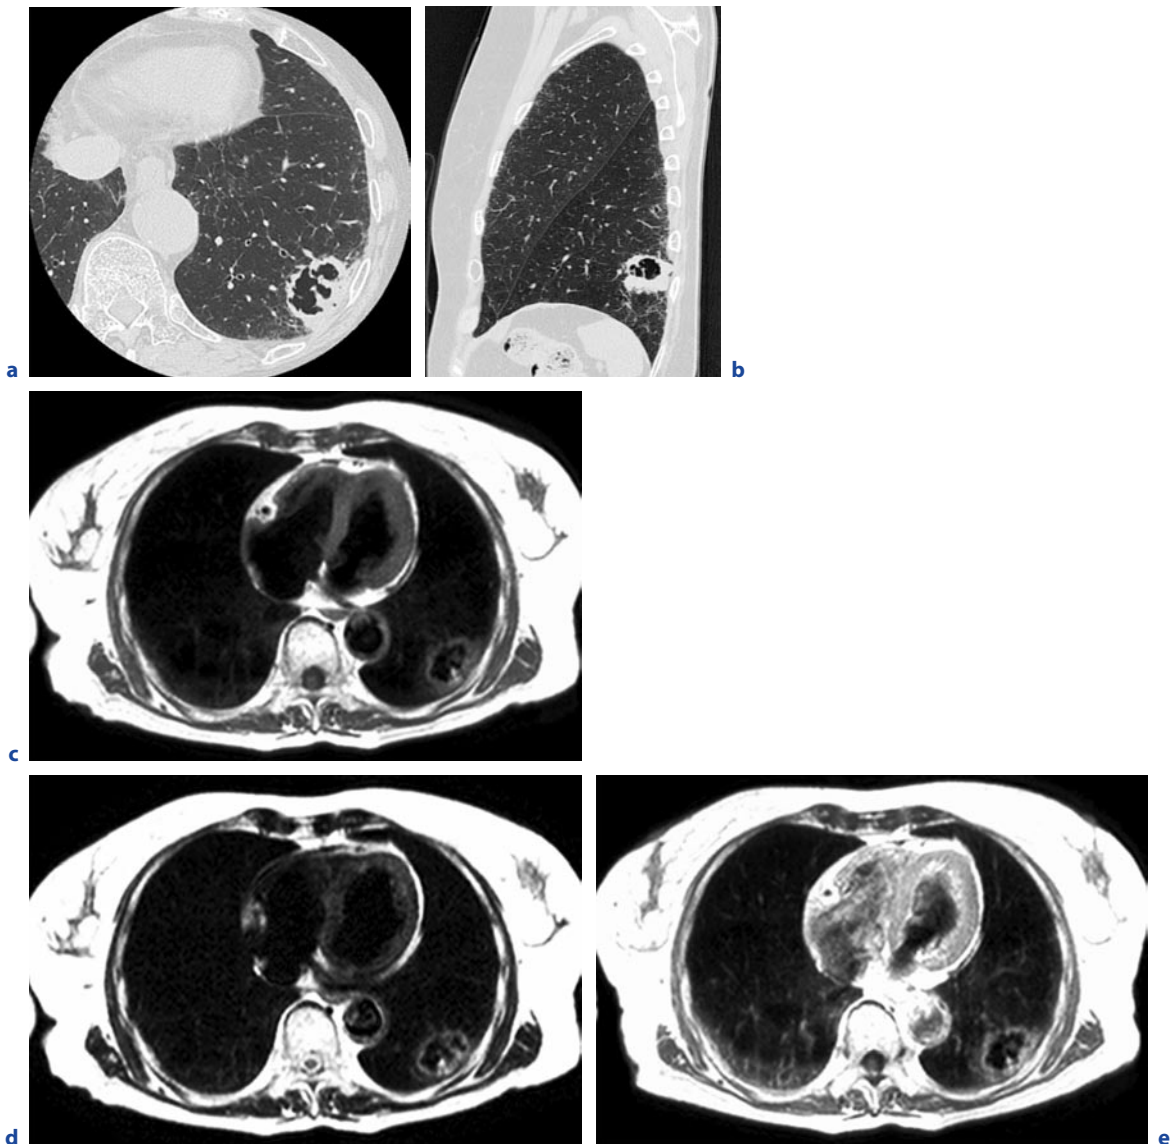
A 74-year-old male with squamous cell carcinoma in the left lower lobe. Thin-section CT (a) and sagittal reformat (b) show mass with irregularly thickened cavity wall in the left lower lobe. Black-blood T1-weighted turbo SE (c) and T2-weighted (d) images show mass with irregularly thickened cavity wall as, respectively, low and high signal intensities in the left lower lobe. Post-contrast black-blood T1-weighted turbo SE (e) image shows well-enhanced cavity wall corresponding to lung cancer
